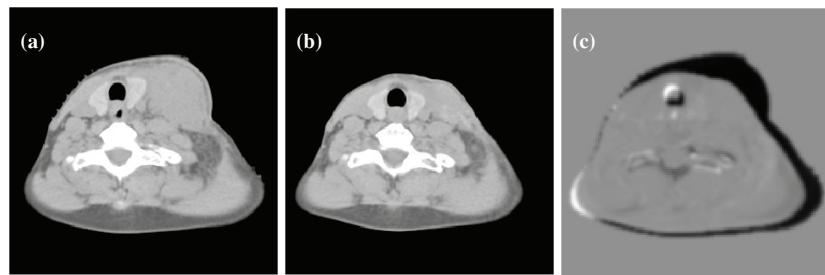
(a) One slice showing the original CT scan in a neck nodal region. (b) Same slice showing the second CT scan taken 37 days after the start of radiation treatment. Note clearly visible shrinkage of anatomy. (c) Difference image of (a) and (b).
